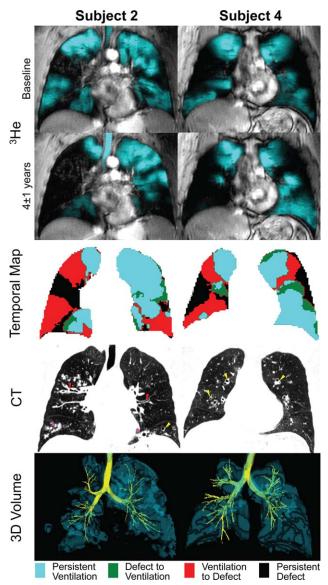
Coronal ³He MRI at baseline and 4 years. Temporal MRI ventilation difference map, CT, and 3D ³He MRI lung volume registered to CT-derived airway tree image for subjects S2 and S4. For the ³He temporal ventilation difference map: black=persistent defect; cyan=persistent ventilation; red=ventilation to defect; green=defect to ventilation. For CT, triangles identify abnormalities spatially related to ventilation defects: yellow triangles identify bronchial dilation and thickening of the bronchial wall for airways in cross-section; red triangles identify in-plane nontapering bronchiectatic airways; purple triangles identify areas of increased density suggestive of mucoid impaction and/or inflammation.
